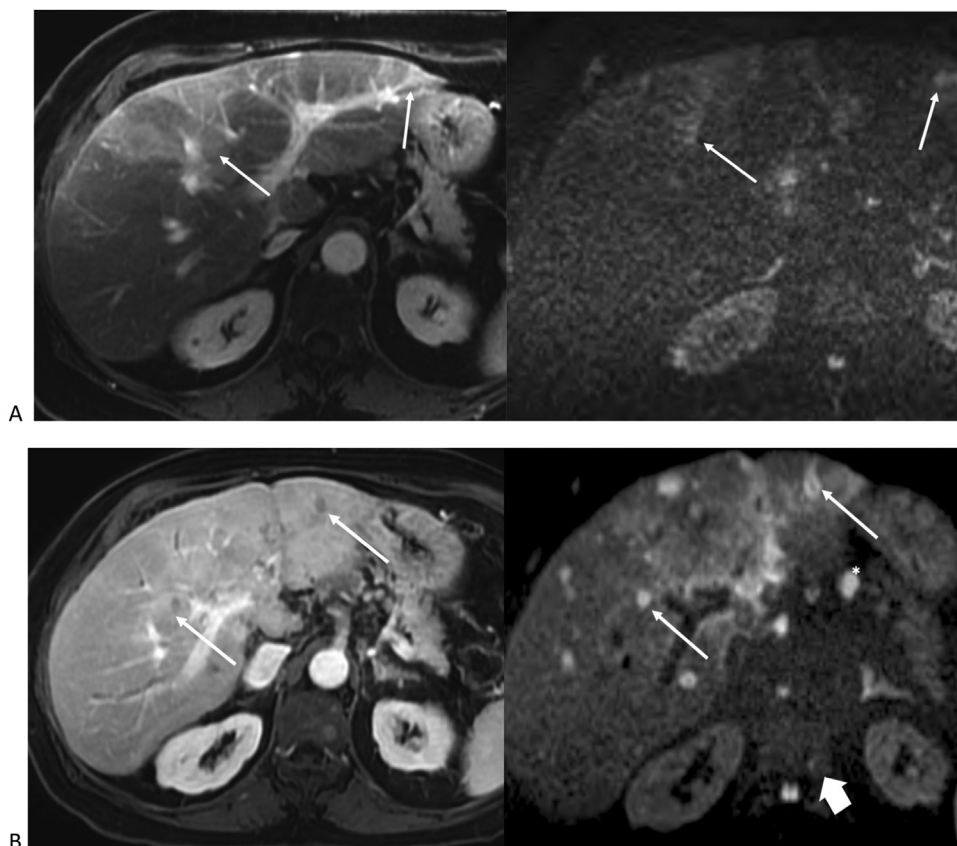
(A) Contrast magnetic resonance T1-weighted imaging (left) performed shortly after biopsy shows geographic areas of altered enhancement but no focal mass. Diffusion-weighted imaging (right) from the same examination reveals subtle foci of restricted diffusion concealed in these areas of fatty infiltration consistent with micro-tumor deposits too small to be detected by computed tomography or ultrasound because of superimposed steatohepatitis. (B) Contrast-enhanced T1-weighted (left) and diffusion weighted (right) magnetic resonance images from examination 2 months after initial diagnosis shows findings of significant disease progression including numerous hypoenhancing and diffusion restricted liver lesions (thin arrows) as well as enhancing vertebral body metastasis (wide arrow) and upper abdominal lymphadenopathy (*).
